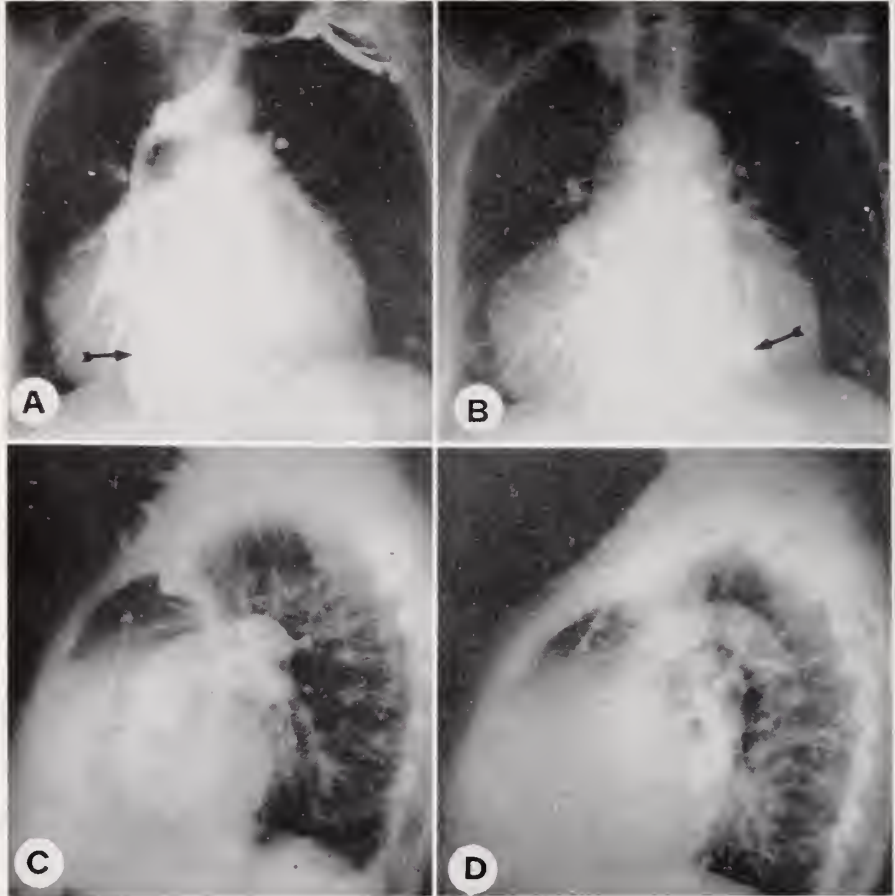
Right angiocardigrams in a patient with a large pericardial effusion. The arrows indicate the wide space between the border of the heart silhouette and the actual cardiac chamber, filled with dye. (From Steinberg, I., *et al.*: *Am. J. Roentgenol.*, 79: 321, 1958. Reprinted by permission of author and Chas. C Thomas Co., Springfield, Ill.)
